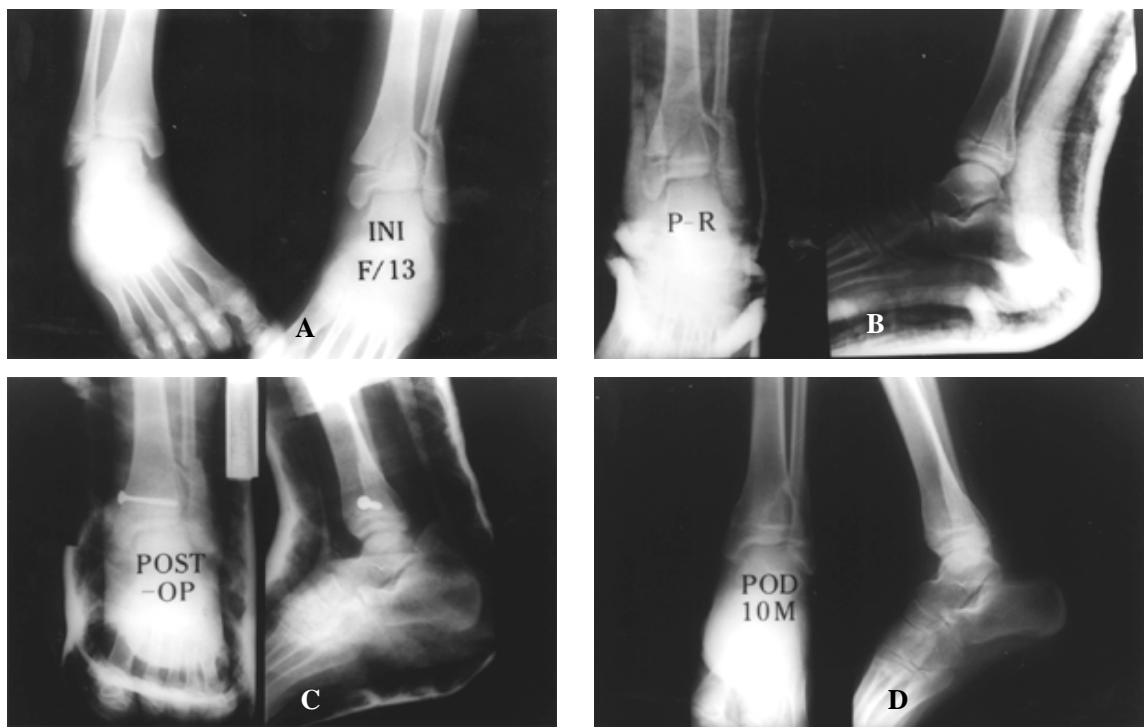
13 years-old female patient. Salter-Harris type II. Initial both AP radiograph shows 4mm displacement compared to contralateral side.
